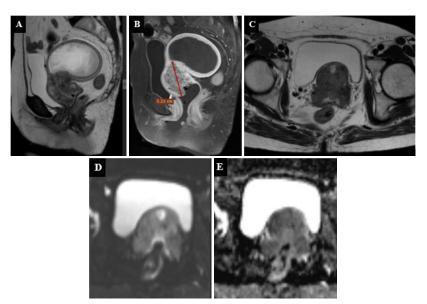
Pelvic MRI Examination with Contrast in Case 3
